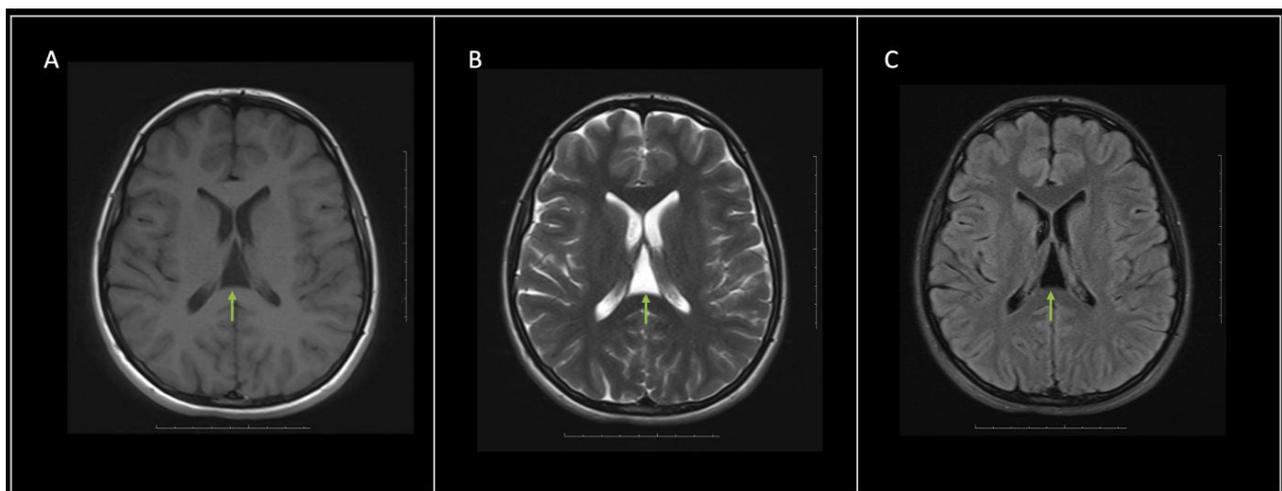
Cavum veli interpositi on brain MRI of a TRD patients
